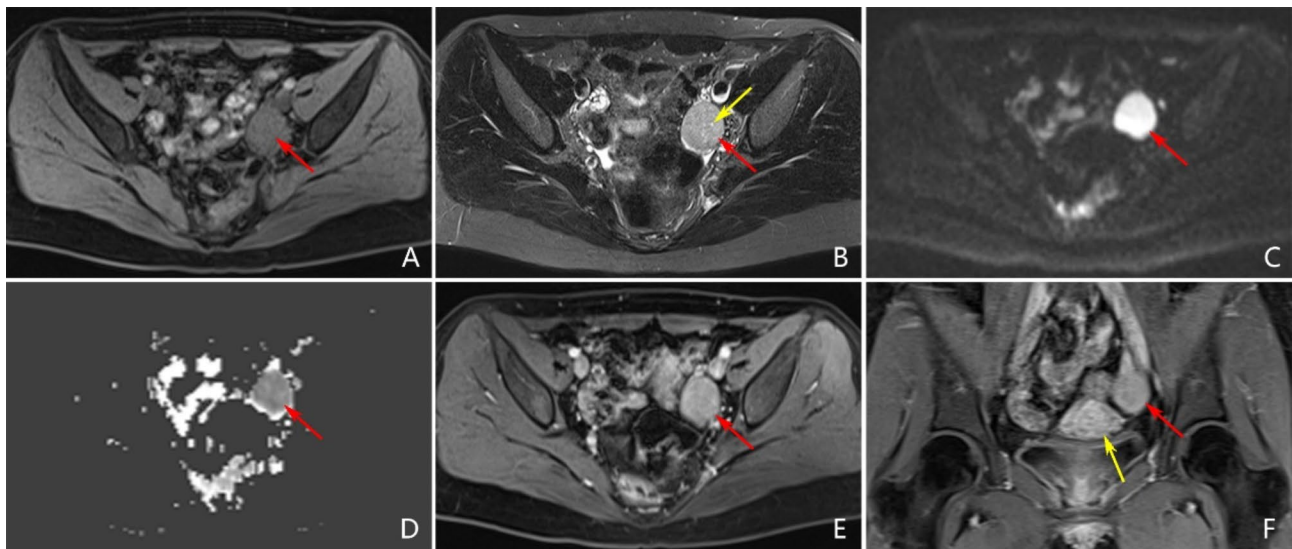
Patient 7, presented with a left ovarian mass for six months, clinically and pathologically confirmed as AGCT-NEL, FIGO stage IC. (A) Axial T₁WI with fat suppression (T₁WI-FS): A solid mass is observed in the left adnexa, well-defined, appearing slightly hypointense on T₁WI (red arrow) with a homogeneous signal. (B) Axial T₂WI with fat suppression (T₂WI-FS): The mass shows slightly hyperintense signal (red arrow), with punctate hyperintense foci noted (yellow arrow). (C) DWI: The mass demonstrates significantly high signal intensity (red arrow). (D) ADCmap: The mass exhibits significantly low signal intensity (red arrow), indicating limited diffusion. (E) Axial view post-contrast scan: The mass shows moderate enhancement (red arrow), and the signal remains homogeneous. (F) Coronal view post-contrast scan: The mass displays uniform enhancement (red arrow), with enhancement intensity lower than that of the myometrium (yellow arrow)
